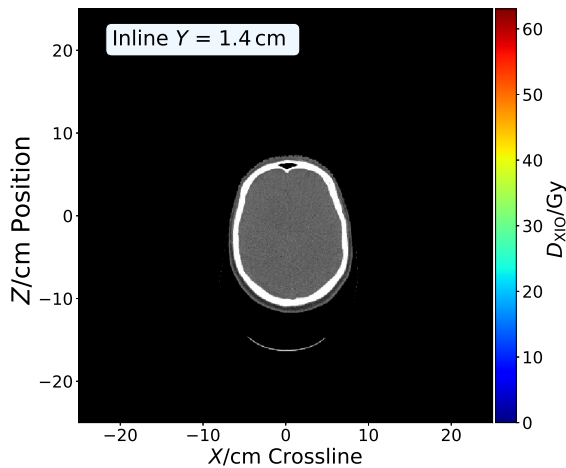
One CT image slice, which belongs to Patient 1. The image is generated at UPTD by using a dual energy CT.
